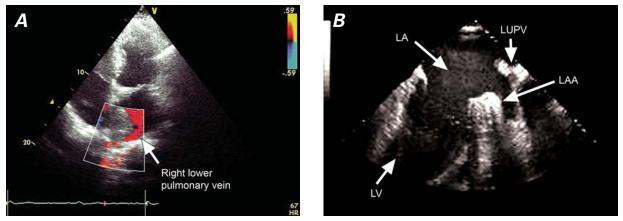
Transesophageal echocardiograms (apical 4-chamber views) show A) the right lower pulmonary vein with patency evaluation by color-flow duplex scan, and B) the left pulmonary veins in B-mode scan.
